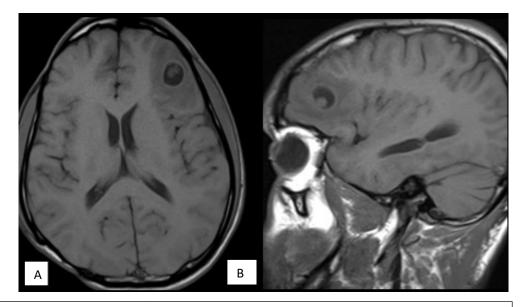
MRI T1W Axial and Saggital images showing Scolex in a case of Neurocysticercosis
